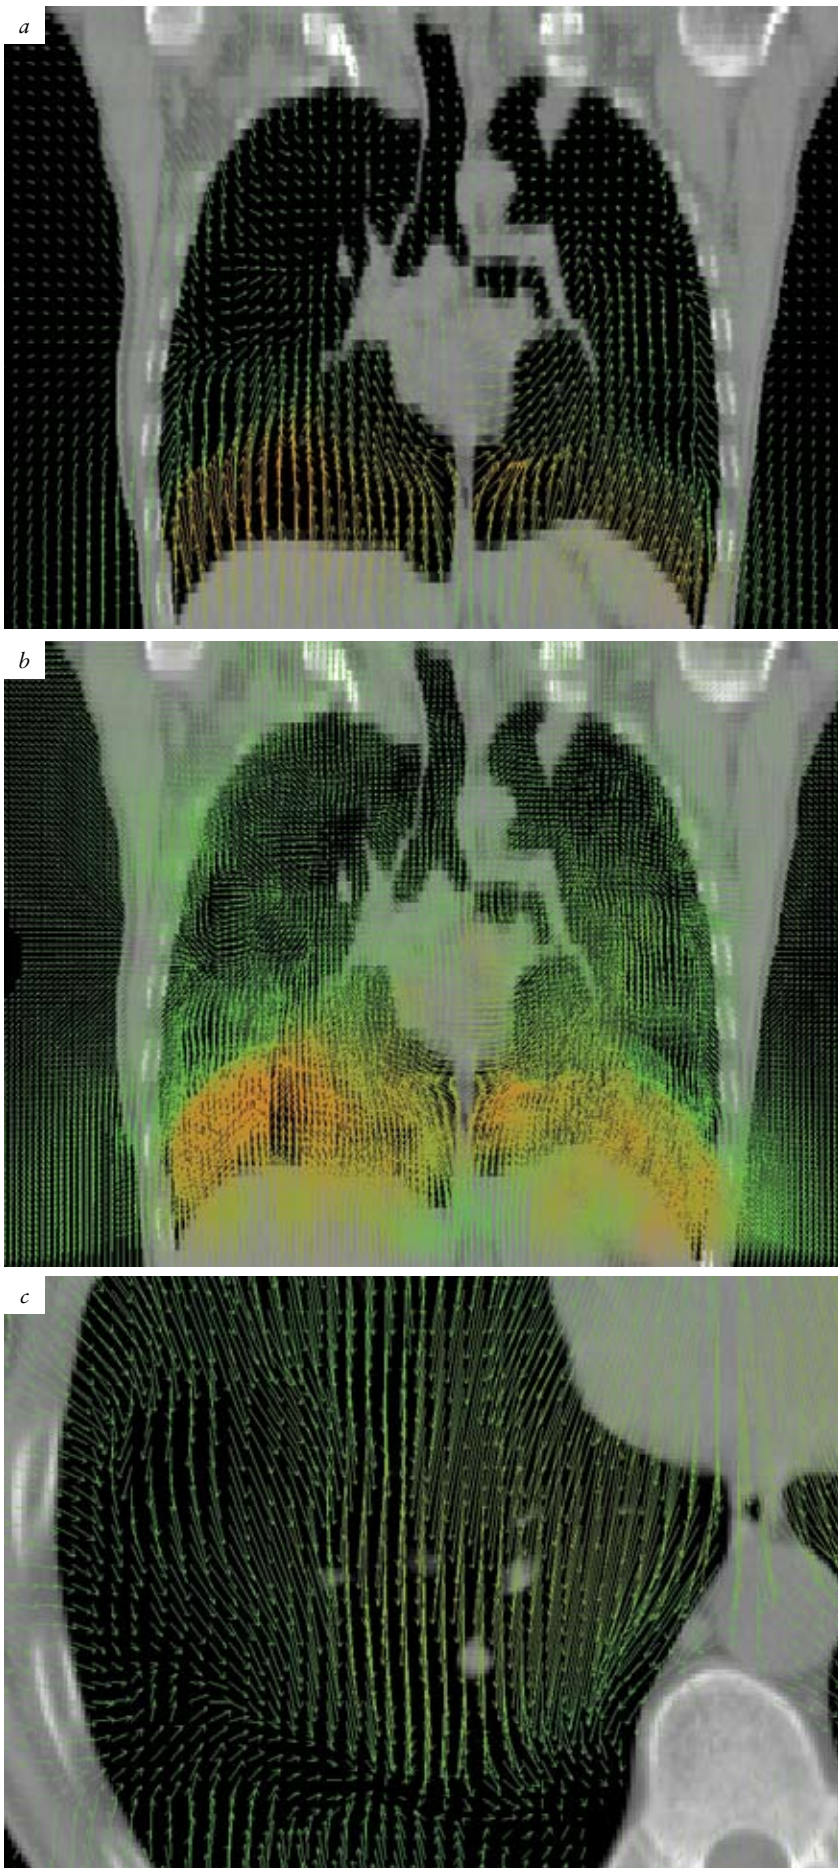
vector field superimposed on CT slices –
